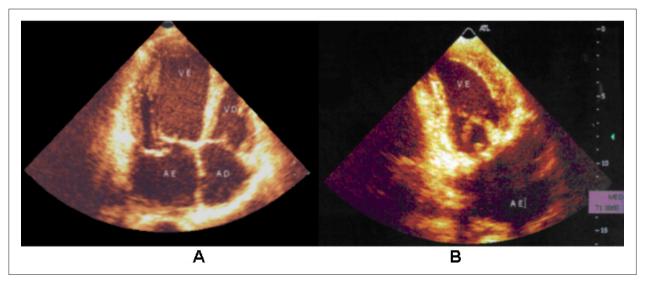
Echocardiographic images highlighting recovery of a more elliptical shape of the left ventricle six months after mitral valve replacement with crossed papillopexy. A - Preoperative; B - Postoperative.
